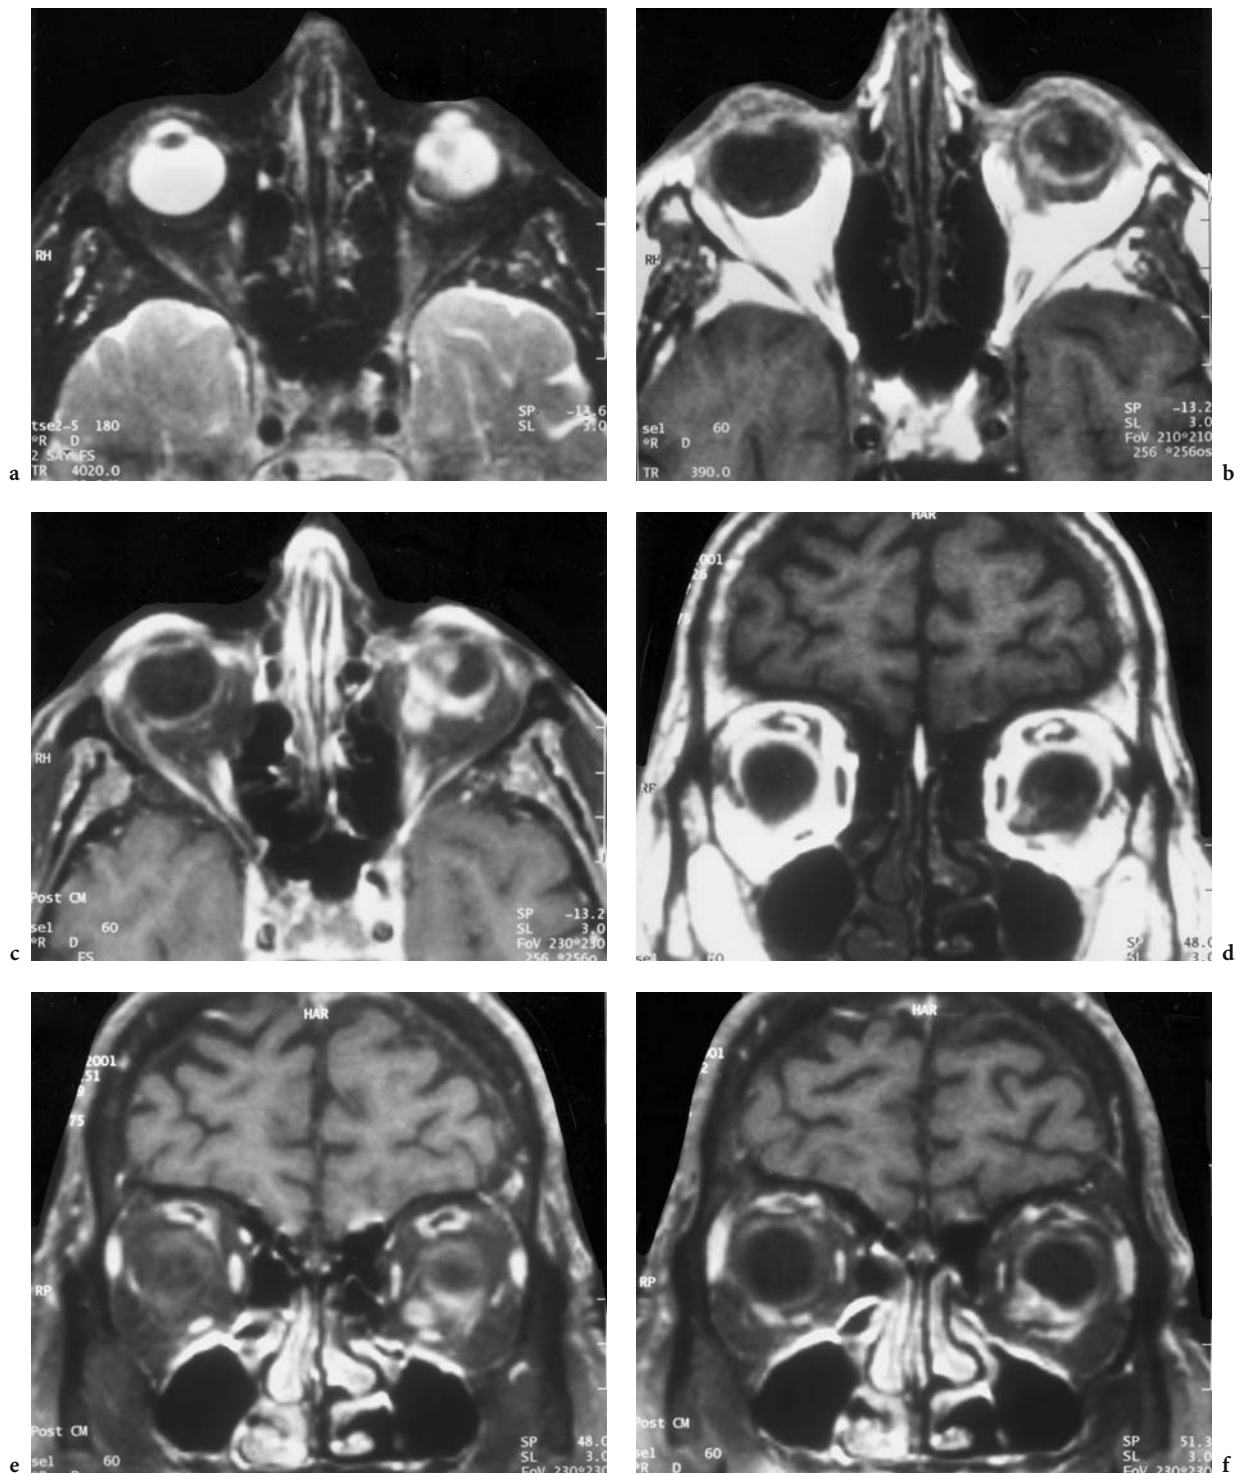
A 73-year-old woman with known malignant melanoma, who had refused therapy for half a year. Diagnosis: malignant melanoma with intraorbital expansion. MRI: a Axial T2-weighted (FS) view of the inferior orbit with irregular hypointense mass in the posterior circumference of the left globe and medial extraocular retrobulbar space. b Corresponding T1-weighted native view, demonstrating the hyperintense signal of the melanoma, apparently infiltrating the posterior choroid. c Corresponding T1-weighted, contrast-enhanced (FS) view with homogeneous enhancement of the tumor, the intraocular mass reaching the inferior ciliary body and lens. Note the similar signal characteristics of the posterior circumference of the globe (representing the infiltrated choroid) and the extraocular tumor. d Coronal T1-weighted native view. e Corresponding T1-weighted, contrast-enhanced (FS) view, where the extraocular expansion between the inferior and medial rectus muscle is best seen. f Coronal T1-weighted, contrast-enhanced (FS) view 3 mm anterior to e with demonstration of the site of rupture of Bruch's membrane
